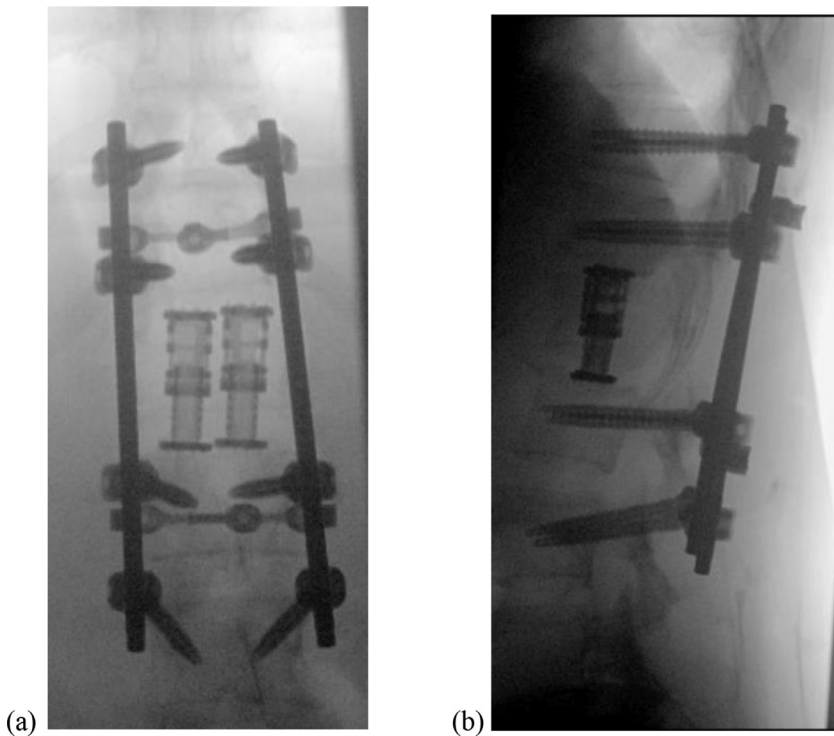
Final intraoperative AP (a) and lateral (b) radiographs for L1 vertebral body reconstruction with bilateral expandable cages.
